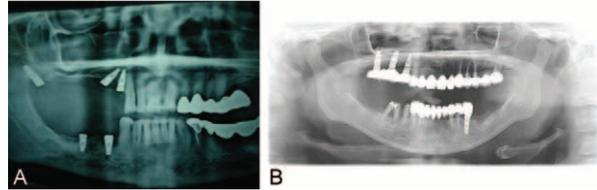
(A) Immediate postoperative panoramic X-ray. (B) Panoramic X-ray showing loading of implants after 6 months.
